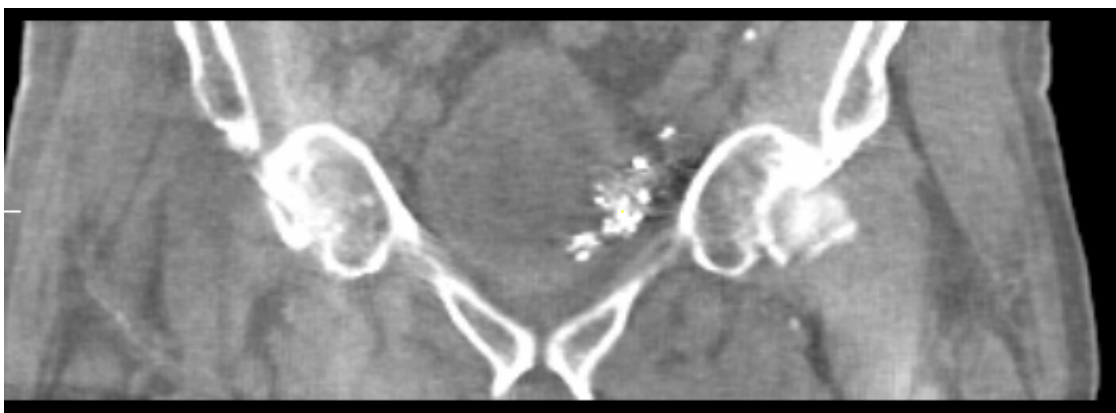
Coronal view of a CBCT image using created preset Bladder A.
